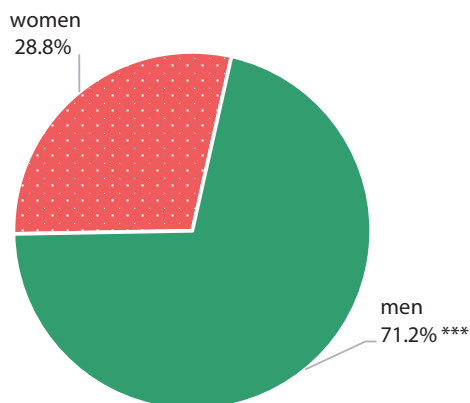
Distribution of patients by sex. All patients underwent a preliminary computed tomography diagnosis.
